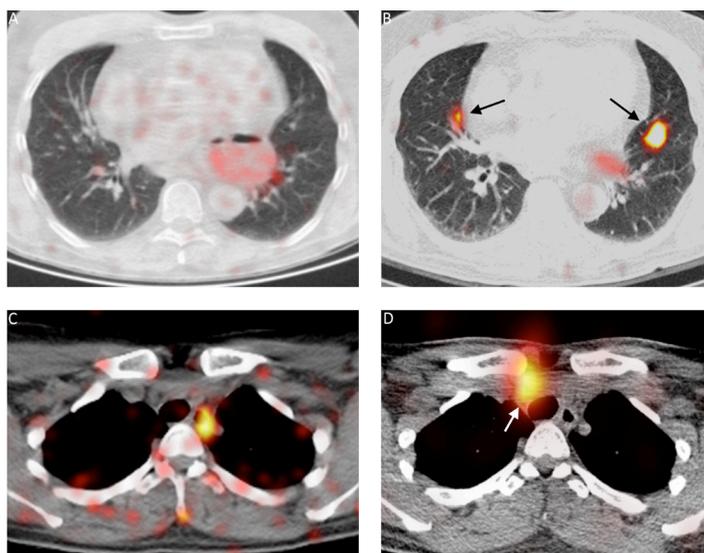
Examples of cases from the THYROPET study¹⁴ where false negative ^{124}I PET/CTs as compared with the ^{131}I SPECT/CT were obtained. ^{124}I PET/CT (A and C) acquired 24 hours after oral administration of 74 MBq ^{124}I and ^{131}I SPECT/CT (B and D) acquired 7 days after oral administration of 7400 MBq ^{131}I , for the first and second patient respectively. The PET/CT scans were acquired using a Philips Gemini in 2 minutes per bed position and a LOR-RAMLA reconstruction without time-of-flight correction (no-PSF no-TOF). The SPECT/CT scans were acquired on a Siemens Symbia T2 in a total scan time of 21 minutes using a Flash3D attenuation corrected reconstruction method (no-SC 6i8s). The arrows indicate the metastatic lesions.
